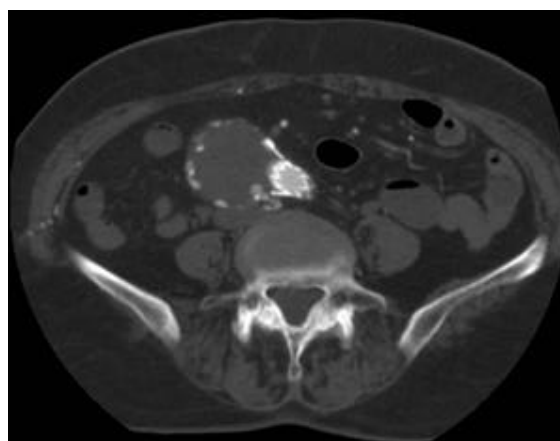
Axial CT scan show retrograde filling (type II endoleak) of contrast media to aneurysmal sac through collateral vessel. Axial CT scan show retrograde filling (type II endoleak) of contrast media to aneurysmal sac through collateral vessel.
